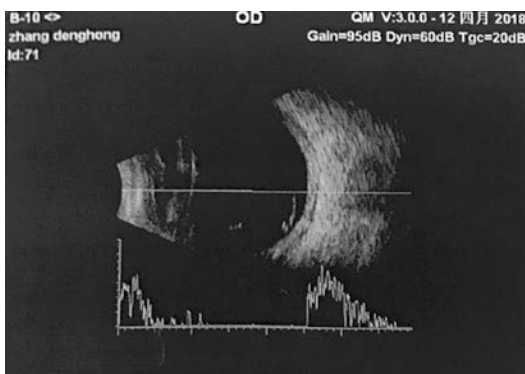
Type-B ultrasonic showed the choroidal thickening of the right eye
